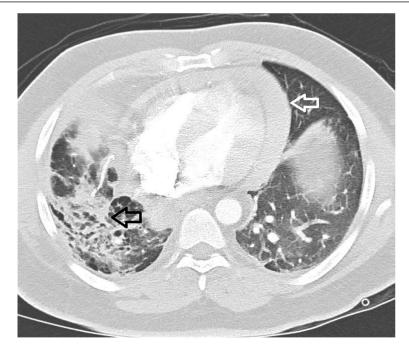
CT Thorax with moderate pericardial effusion (white arrow) and pulmonary sarcoid with fibrosis (black arrow)
